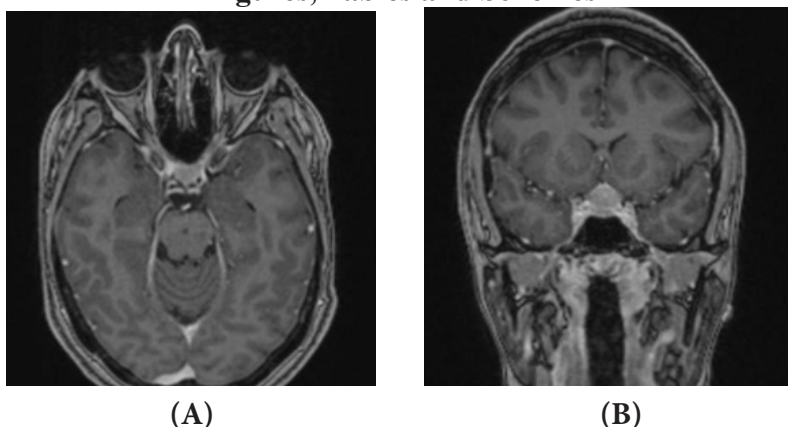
Preoperative MRI Assessment. (A) Axial T1-weighted Sequence and (B) Coronal T1-Weighted Sequence Confirming a Planum Sphenoidale Meningioma with Superior Extension and Compression of the Optic Chiasm.
